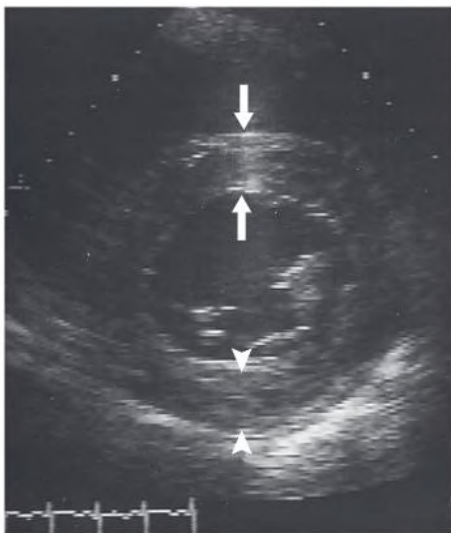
Echocardiogram Showing Concentric Left Ventricular Hypertrophy. Septal thickness (*between arrows*) and posterior wall thickness (*between arrowheads*) are increased (to 16 mm) in a patient with primary hypertension (normal is ≤ 11 mm). (Courtesy A. Pearlman, University of Washington.)
